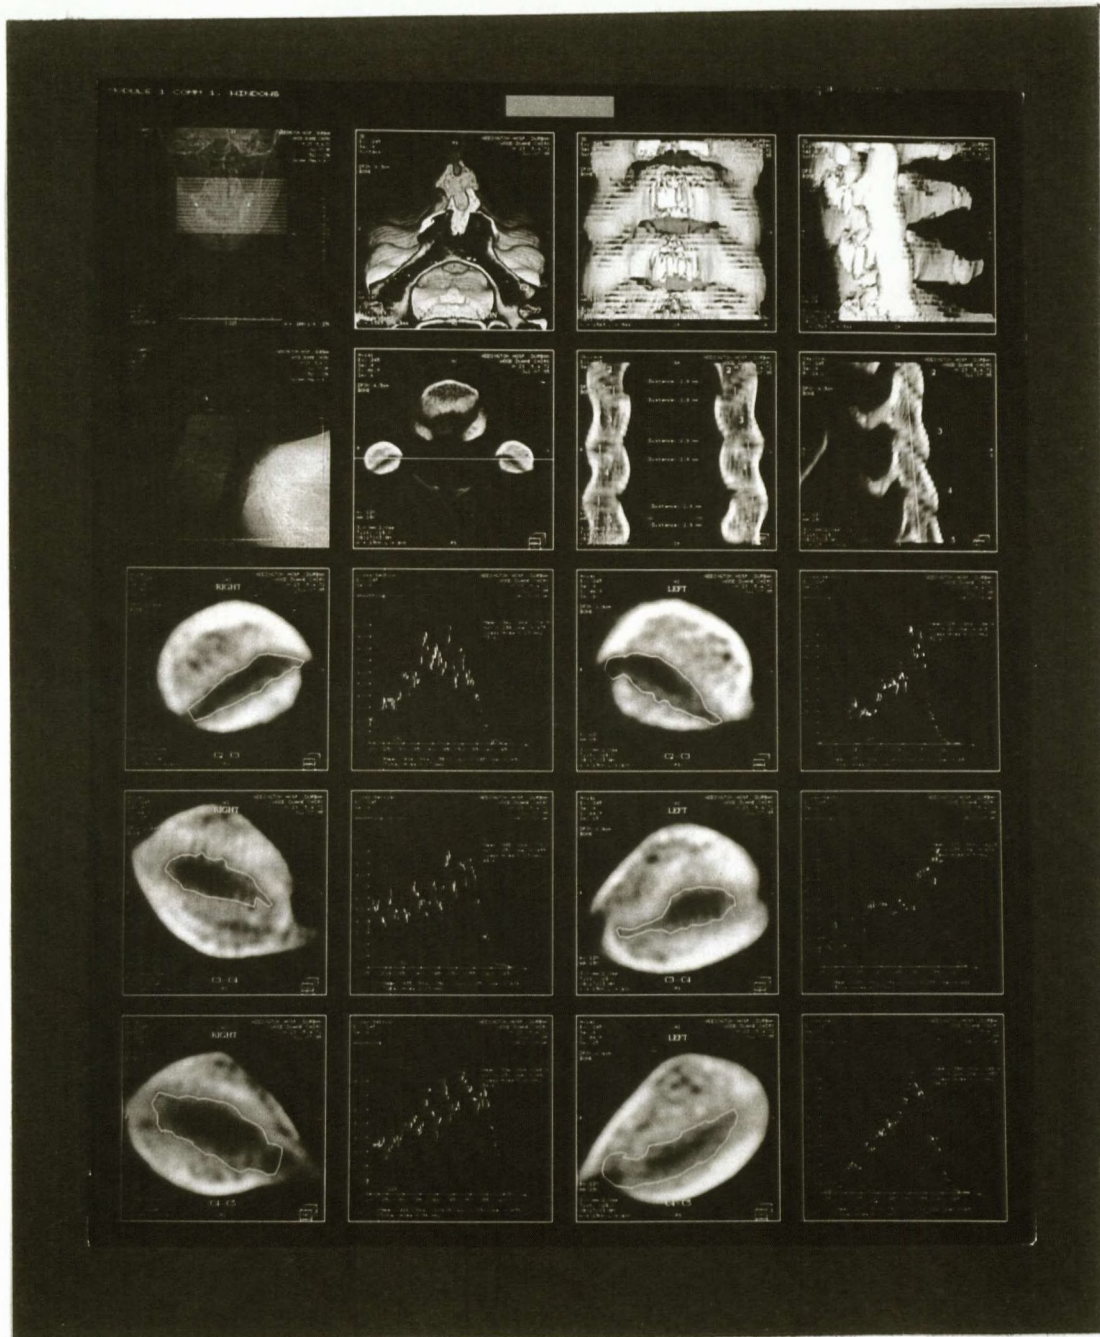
Experiment 4 : Post-manipulation + 8kg traction CT scan
